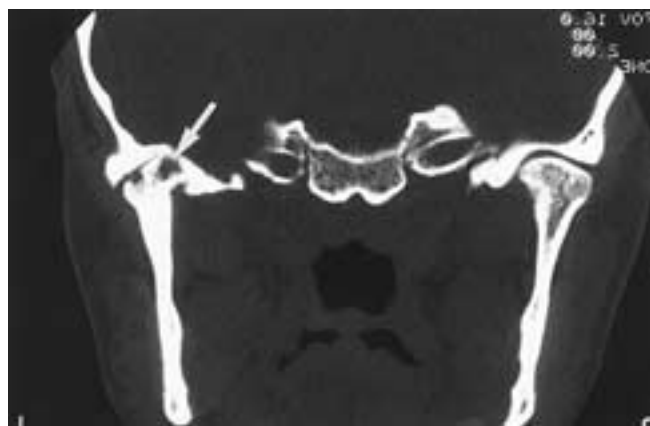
Erosions and bony ankylosis following temporary Silastic implant. Coronal CT scans through the TMJ show extensive erosive changes of the right condyle. There is bony ankylosis between the condyle and the glenoid fossa and the medial part of the joint. The patient used a temporary Silastic implant for a few months. These extensive radiographic changes are the sequelae from the use of the implant.
